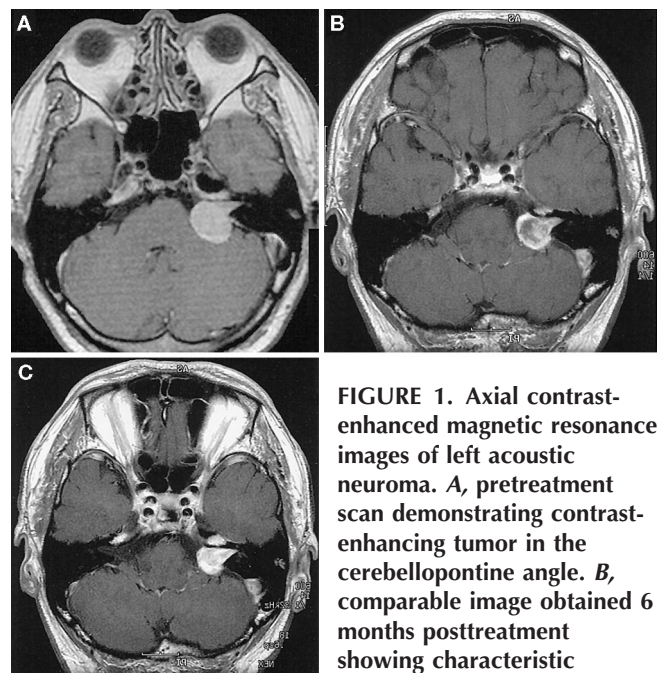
Axial contrast-enhanced magnetic resonance images of left acoustic neuroma. A, pretreatment scan demonstrating contrast-enhancing tumor in the cerebellopontine angle. B, comparable image obtained 6 months posttreatment showing characteristic decreased central contrast enhancement. C, image obtained 18 months posttreatment showing a decrease in the tumor size and recovery of some contrast enhancement.
